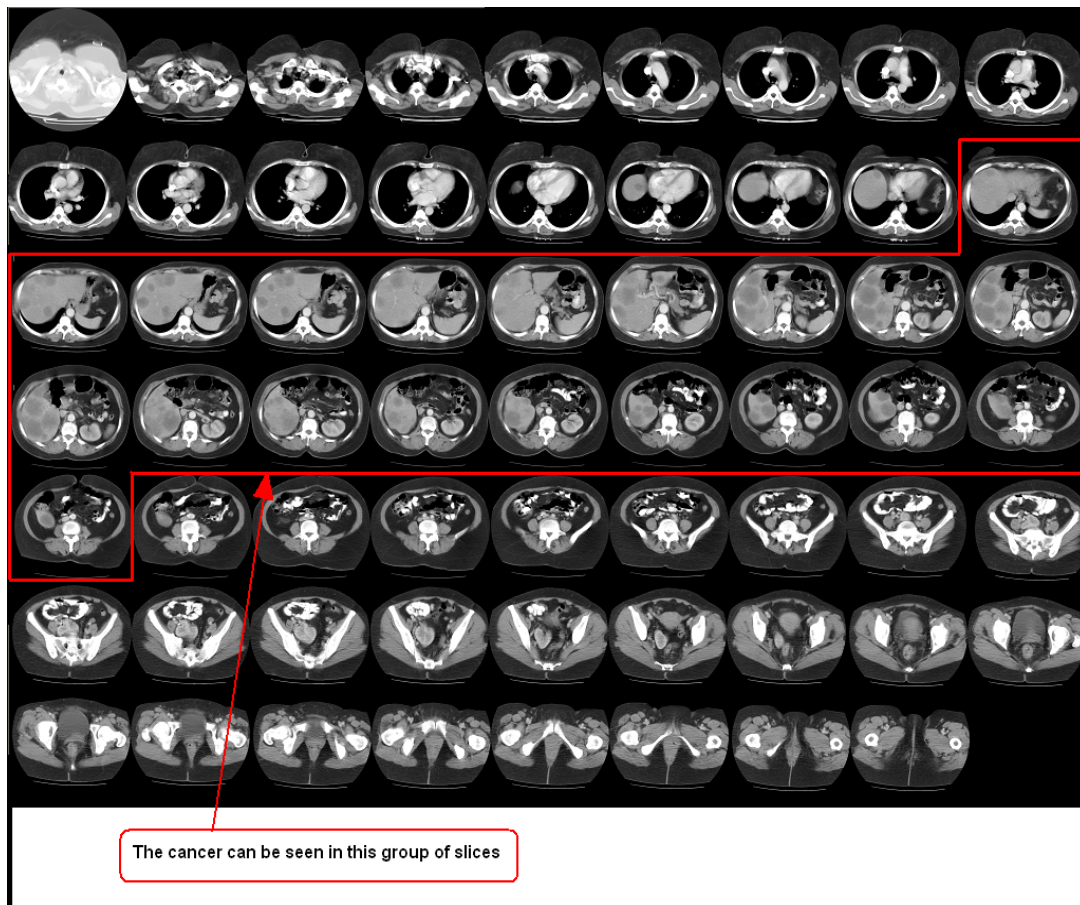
CT scan for female abdomen diagnosed with a liver cancer
